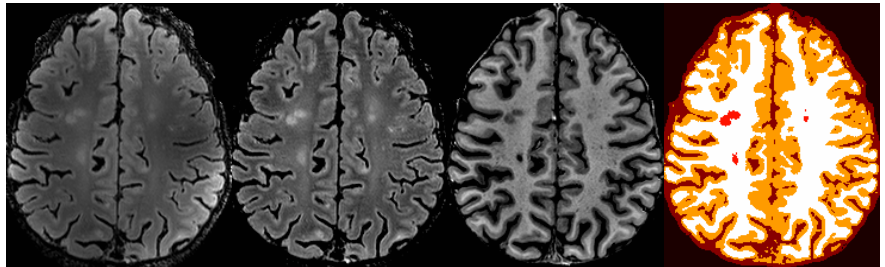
Typical “dura-stripped” 7T images of an MS patient. From left to right: FLAIR without N4-correction, N4-corrected FLAIR, N4-corrected, MPRAGE and final segmentation (white – white matter, orange – gray matter, light red – lesions, and dark red – cerebrospinal)
